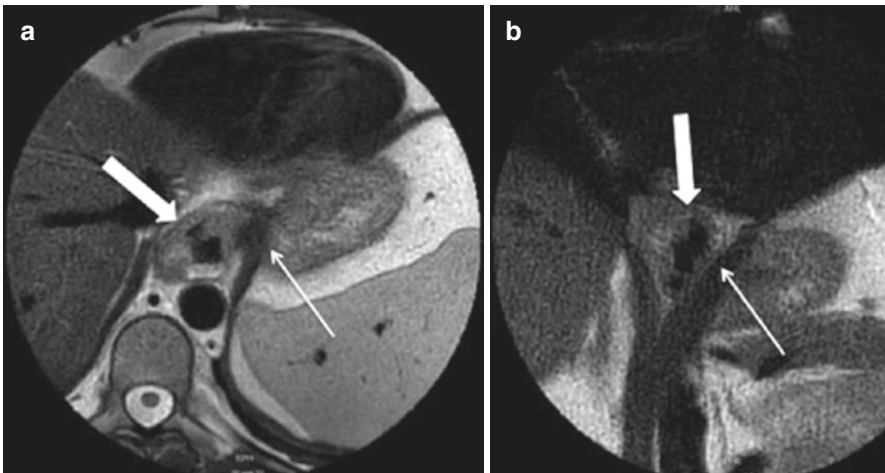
Wrap rupture with recurrent hernia on MRI. Complete wrap disruption obtained in a patient with symptoms of recurrent reflux. The typical “pseudotumor” is missed on the axial (a) and coronal (b) view (thin arrows). A recurrent axial hernia is now demonstrated (thick arrows). (Images courtesy to C. Kulinna-Cosentini, MD, Department of Biomedical Imaging and Image-guided Therapy, Medical University of Vienna)
